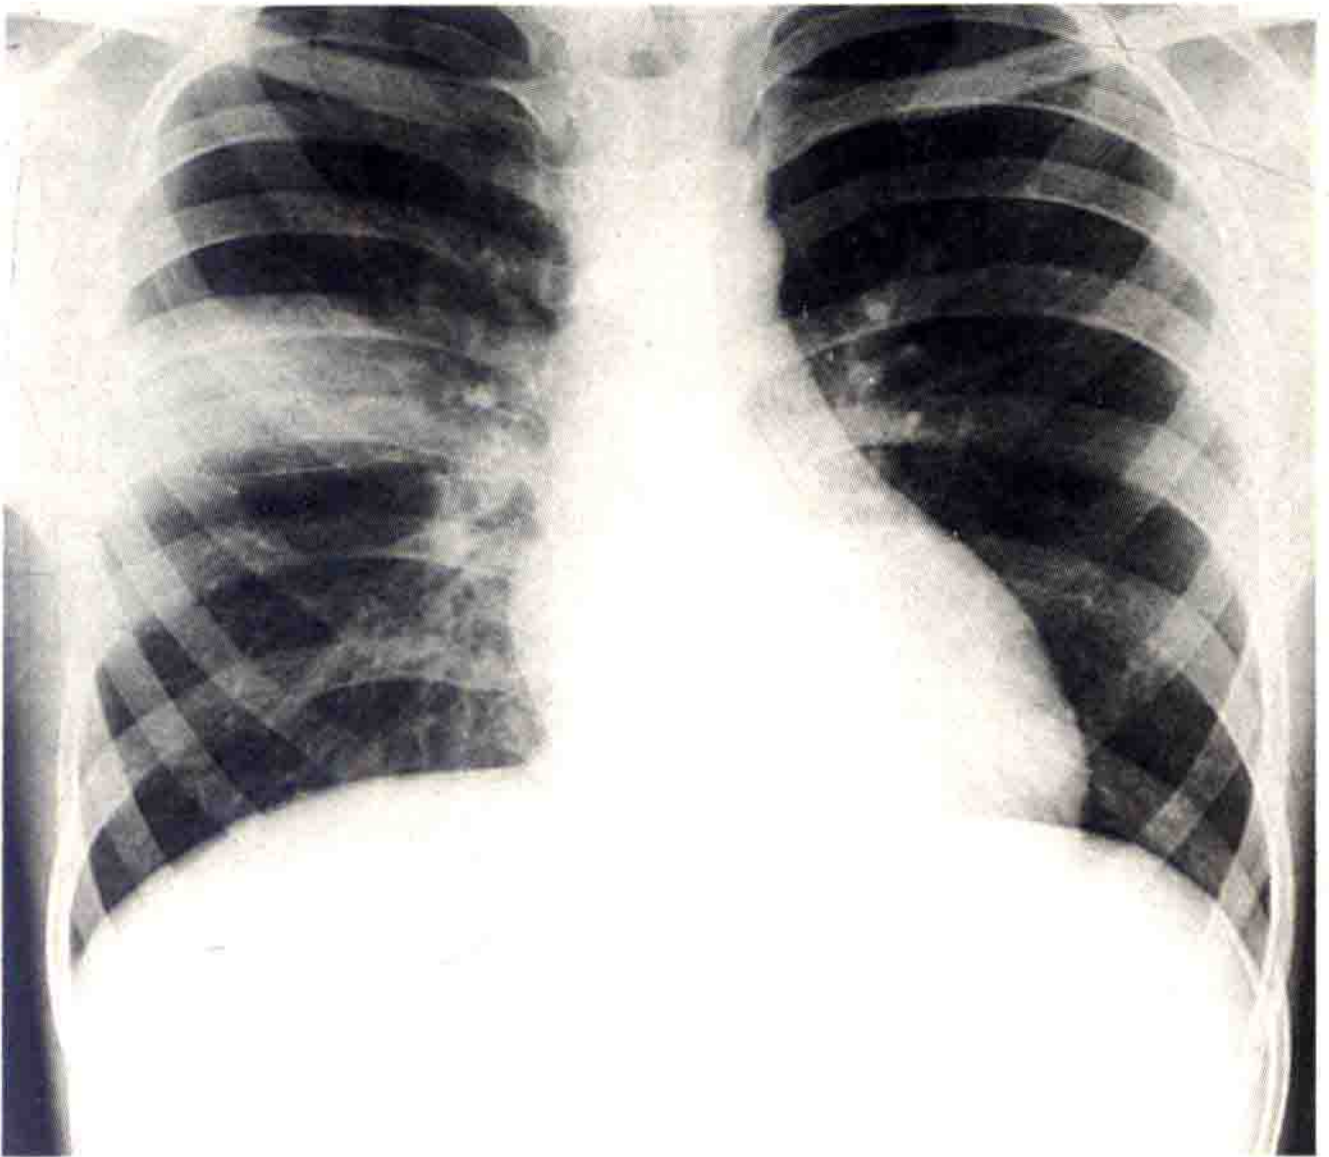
Pneumococcal pneumonia is characterized by its sudden onset accompanied by rigors, high fever, pleural pain, rusty sputum and neutrophilia. This 'classical' form is now uncommon in wealthier countries. Nevertheless, *Streptococcus pneumoniae* remains the dominant cause of community-acquired pneumonia and is common also in nosocomial pneumonia. Consolidation may involve a complete lobe or, as in this radiograph, a segment.
